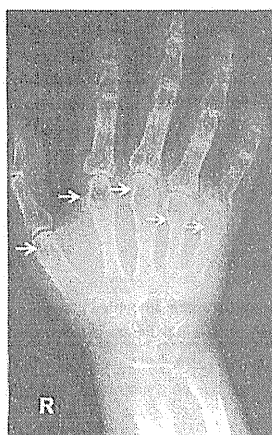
Plain X-ray images of hands and fingers. Multiple bone cysts were found at the epiphyses (arrow).
